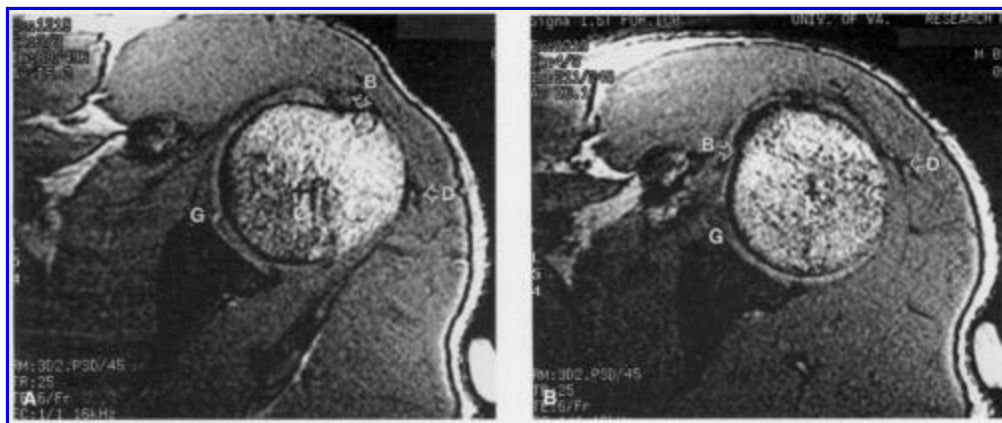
(A) Magnetic resonance imaging axial view of shoulder with the arm at the subject's side, actively held in maximal active external rotation with the elbow extended. B = bicipital groove; C = center of humeral head in relation to articular surface; D = deltoid raphe; G = anterior glenoid. (B) Magnetic resonance imaging axial view of same subject with maximal active internal rotation, elbow extended. Note the position change of points B and D.
